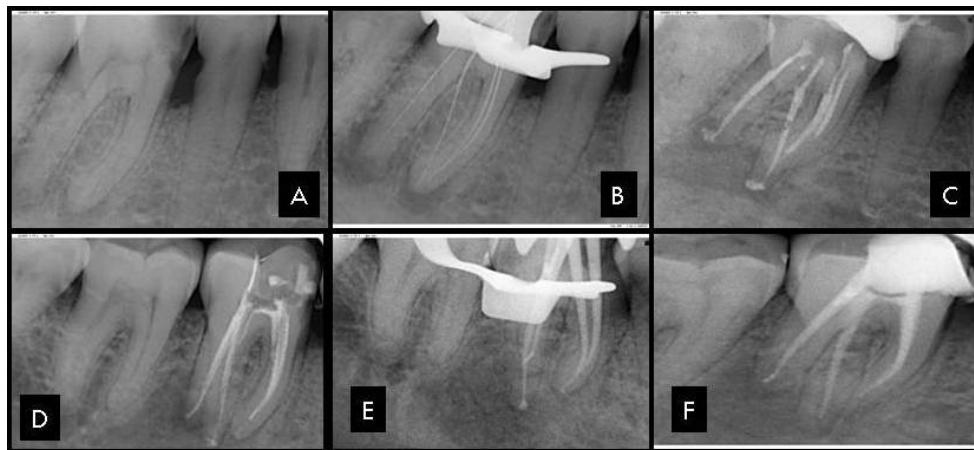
A- Pre-operative radiograph; B- Working length radiograph; C- Intracanal Medicament placed; D- After 1month follow up; E- Mater Cone Selection; F- Obturation followed by post endodontic treatment.
